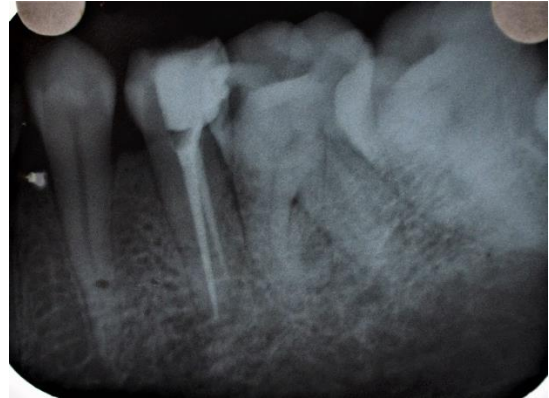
Post-operative radiograph with tooth #35.
